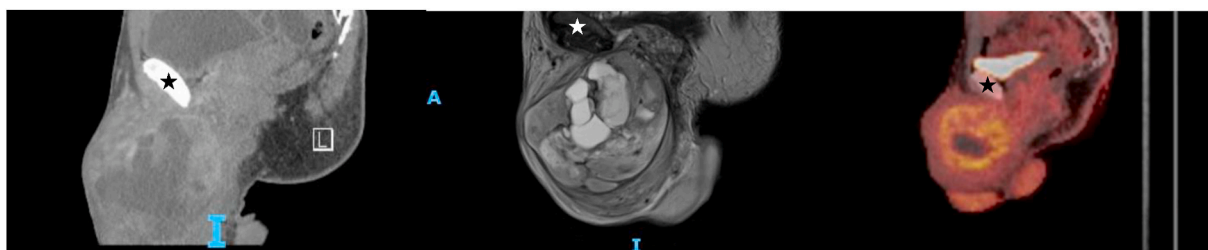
Sagittal imaging of a large scrotal mass (left to right: CT, MRI, PET/CT; anterior is left of photo, inferior is bottom of photo; star marks pubic bone).
